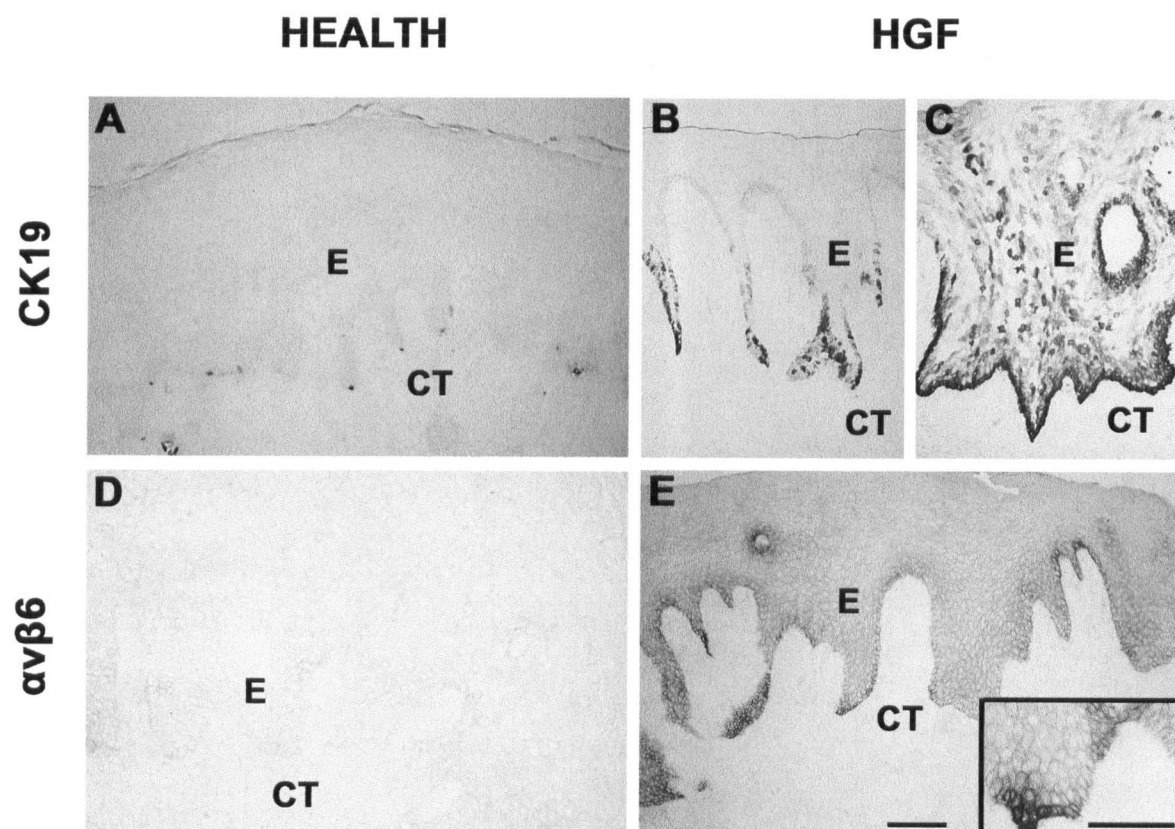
Expression of cytokeratin 19 (CK19; A-C) and $\alpha\text{v}\beta\text{6}$ integrin (D and E) in marginal gingiva in health (A and D) and hereditary gingival fibromatosis (B, C and E). E = epithelium; CT = connective tissue. Bar 100 μm
